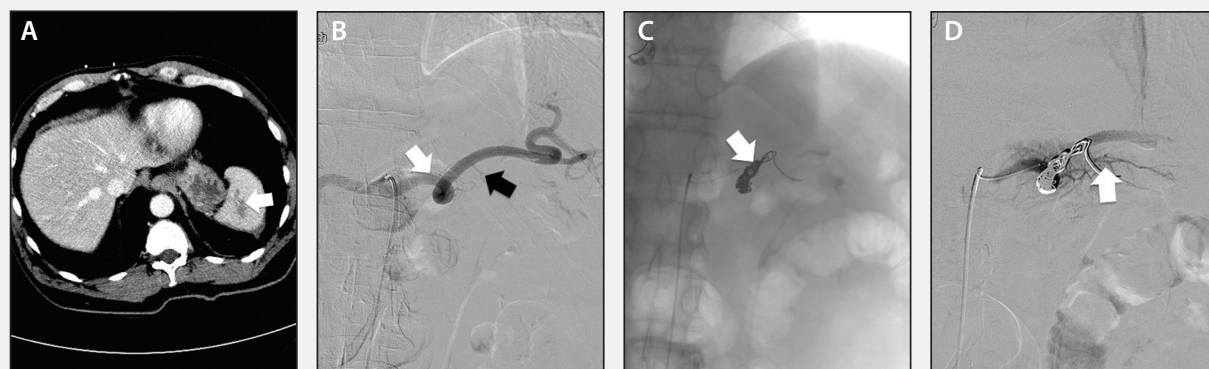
A patient with a grade III splenic laceration. Contrast-enhanced axial CT image demonstrating grade III splenic laceration (white arrow) (A). DSA from the celiac artery demonstrating the splenic artery (white arrow) and the pancreaticoduodenal artery (black arrow) (B). Spot radiograph after successful deployment of a POD 8-mm anchoring coil and a Packing Coil (white arrow) (C). DSA demonstrating complete occlusion of the mid-splenic artery with preserved collateral flow to the spleen (white arrow) (D).
